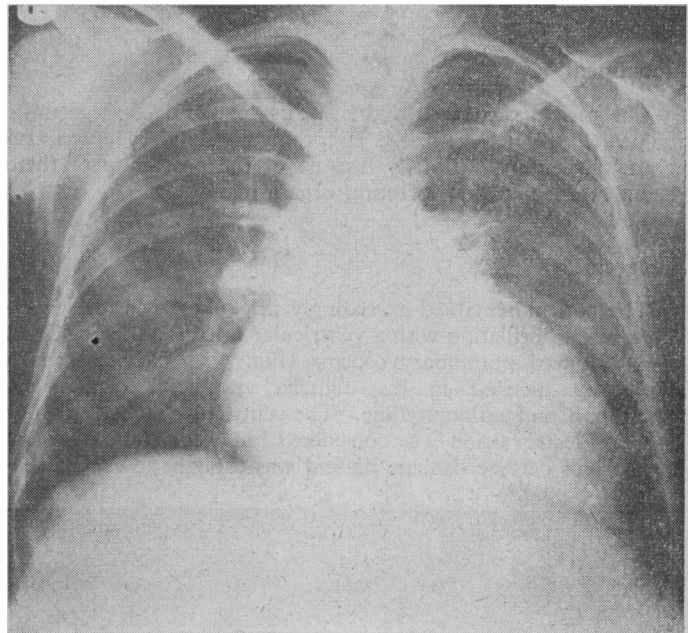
6 ft. postero-anterior chest radiograph on 24 April 1964, showing massive cardiac enlargement, mainly of the left ventricle and subacute pulmonary oedema. The aorta and main pulmonary arteries are enlarged, and the right atrium prominent.
